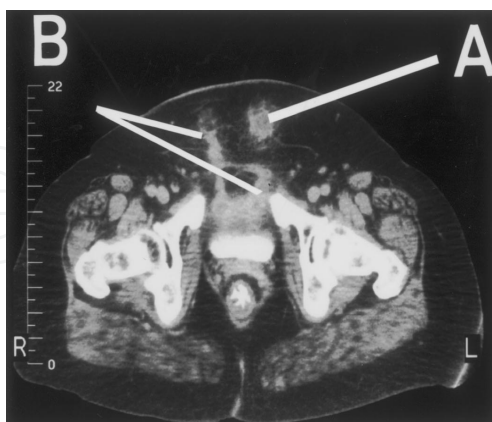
CT shows inflammation of subcutaneous tissue (A) and along arms of the SIS sling (Ho et al, 2004).
